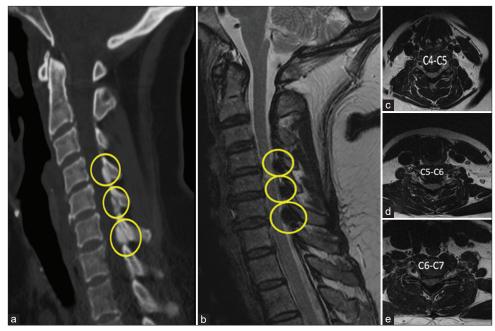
Sagittal Computed tomography (a), T2-weighted Magnetic resonance imaging (b), and (c,d,e) Axial T2-weighted images of calcium pyrophosphate dehydrate (CPPD) deposit disease in the cervical ligamentum flavum (CLF) of a 60-year-old female with cervical myelopathy presenting with balance and gait abnormalities. Sagittal yellow images circle (a,b) denotes a CPPD compression lesion in C4-C5, C5-C6, and C6-C7 CLF lamina. Axial images present spinal canal stenosis.
